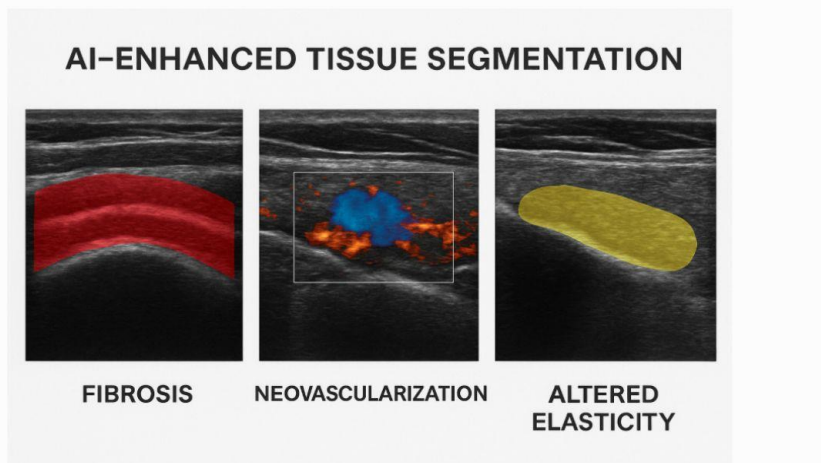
AI-enhanced tissue segmentation showing identification of fibrosis, neovascularization, and altered elasticity in ultrasound images.
